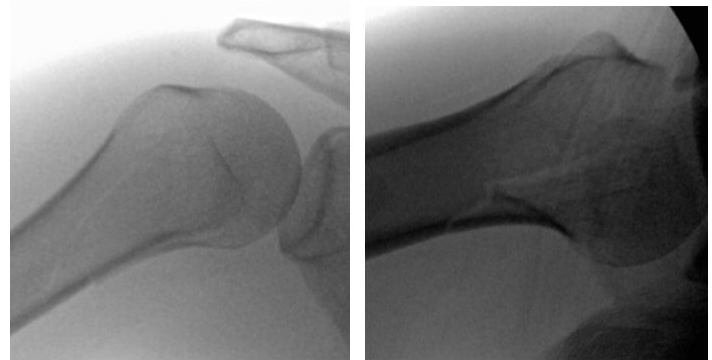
Initial AP and Scapular Y plain film views demonstrating a proximal humerus fracture-dislocation.
